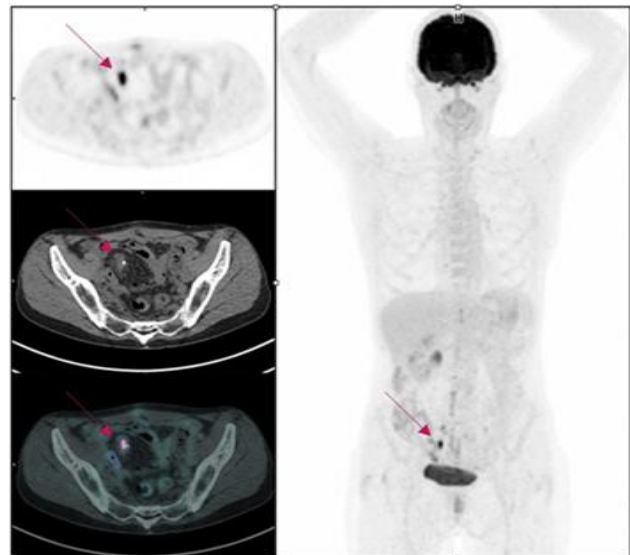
A 57-year-old woman with ovarian cancer underwent FDG PET/CT imaging for pretreatment purposes. (Upper left) Transverse PET image shows an area of focal abnormal FDG uptake in right iliac fossa (arrow). (Middle left) Transverse CT image shows corresponding mesenteric implant (arrow) adjacent to a metallic clip. (Lower left) Transverse fused PET/CT image again shows 1.7 cm mesenteric implant (arrow) with high
